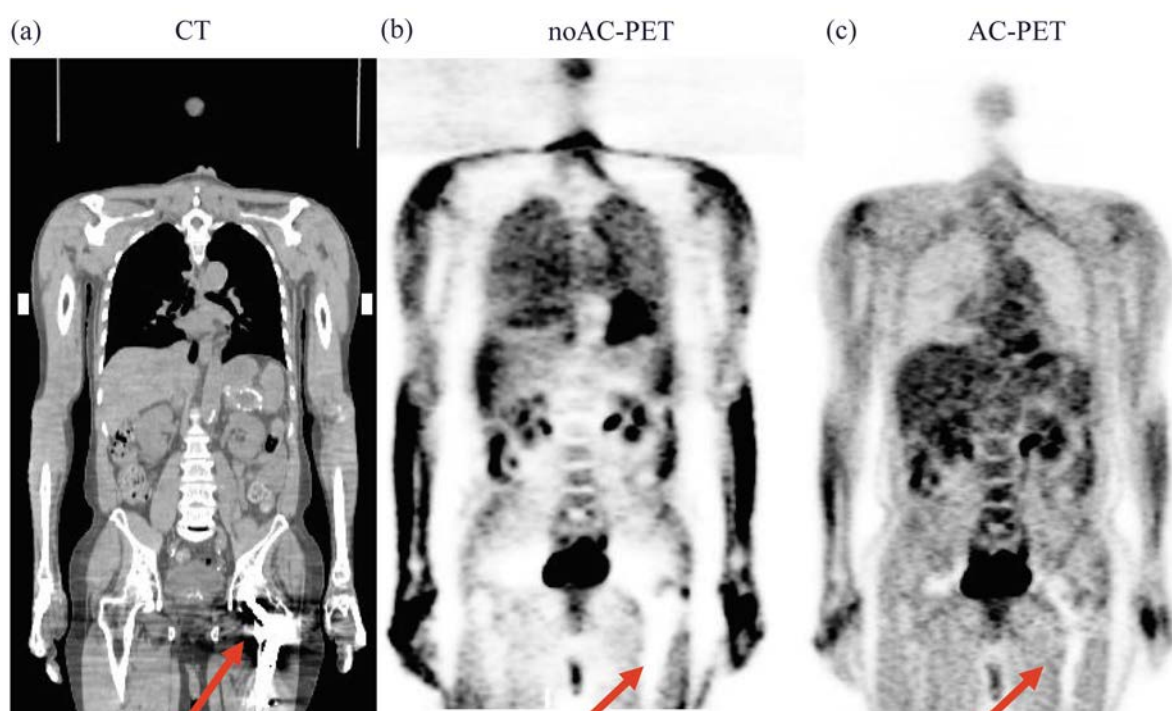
Coronal image planes of whole body CT (a), noAC-PET (b) and AC-PET (c) from a patient PET/CT study with a metallic hip prosthesis. AC: attenuation corrected; noAC: not attenuation corrected.
